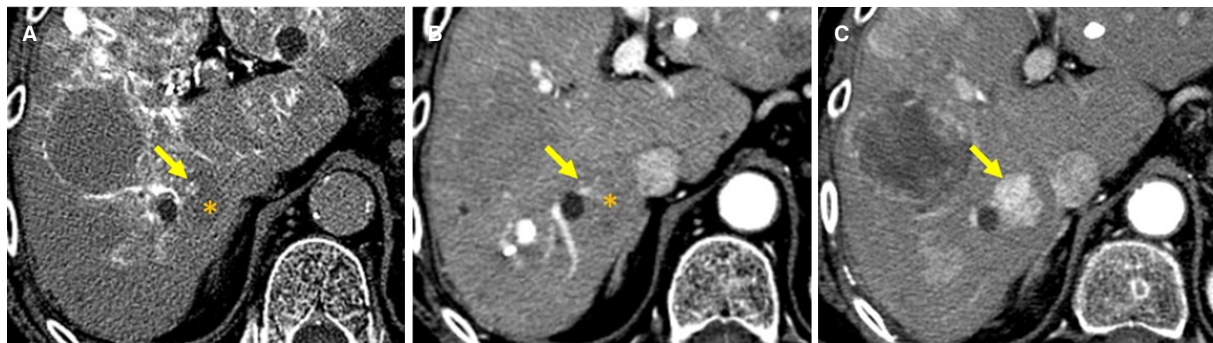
Development of hepatocellular carcinoma from hypovascular nodule with hypervascular foci. A, B: on CT during hepatic arteriography (A) and arterial phase of dynamic CT (B), small hypervascular foci (arrow) is observed within hypovascular nodule (*); C: eleven months after, on arterial phase of dynamic CT, the hypovascular nodule with hypervascular foci transformed to hypervascular hepatocellular carcinoma (arrow)
